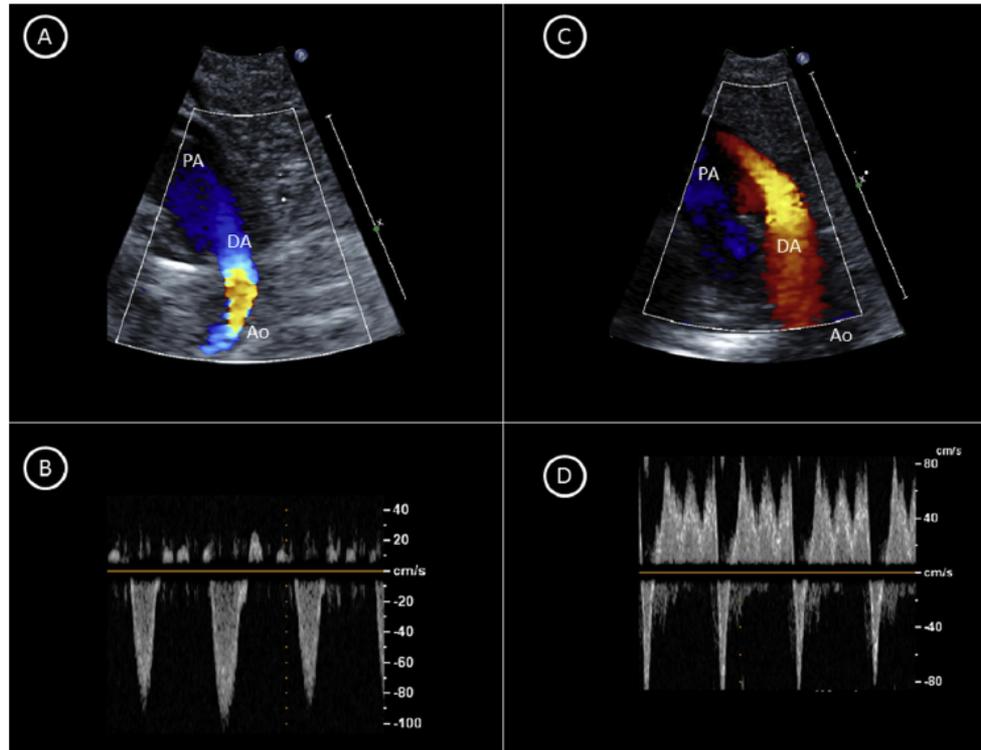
Left high parasternal ultrasound view of the pulmonary artery trunk (PA), ductus arteriosus (DA) and aorta (Ao) in a preterm infant with pulmonary hypertension after PPRM. A, Color Doppler view of pulmonary hypertension, *blue* indicating blood flowing away from the probe in all 3 vessels. B, Pulse-wave Doppler analysis of the waveform in the ductus arteriosus, right-to-left shunt is directed downwards. C, Color Doppler pattern 5 minutes after iNO was started and improved oxygenation was seen. *Red* in the ductus arteriosus indicates blood flowing towards the probe and towards the pulmonary trunk, and *blue* in the pulmonary trunk and aorta. D, Pulse-wave analysis now shows bidirectional flow velocity, with most of it going left-to-right, or upwards.
